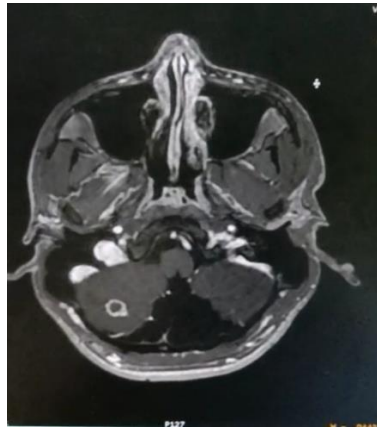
MRI brain with contrast
